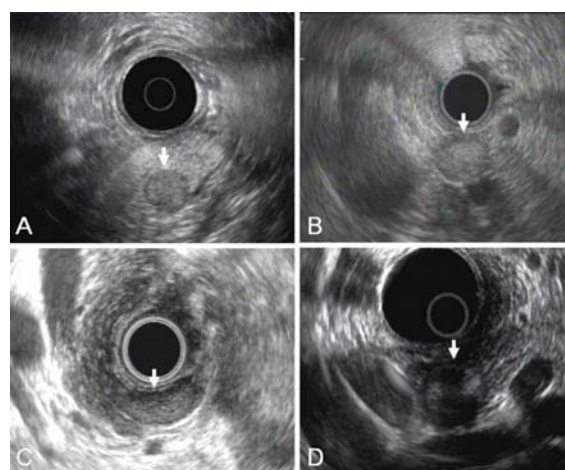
The 4 endosonographic features of insulinoma by EUS. A) hypoechoic nodule B) hyperechoic nodule C) isoechoic nodule D) mixed echogenicity nodule
